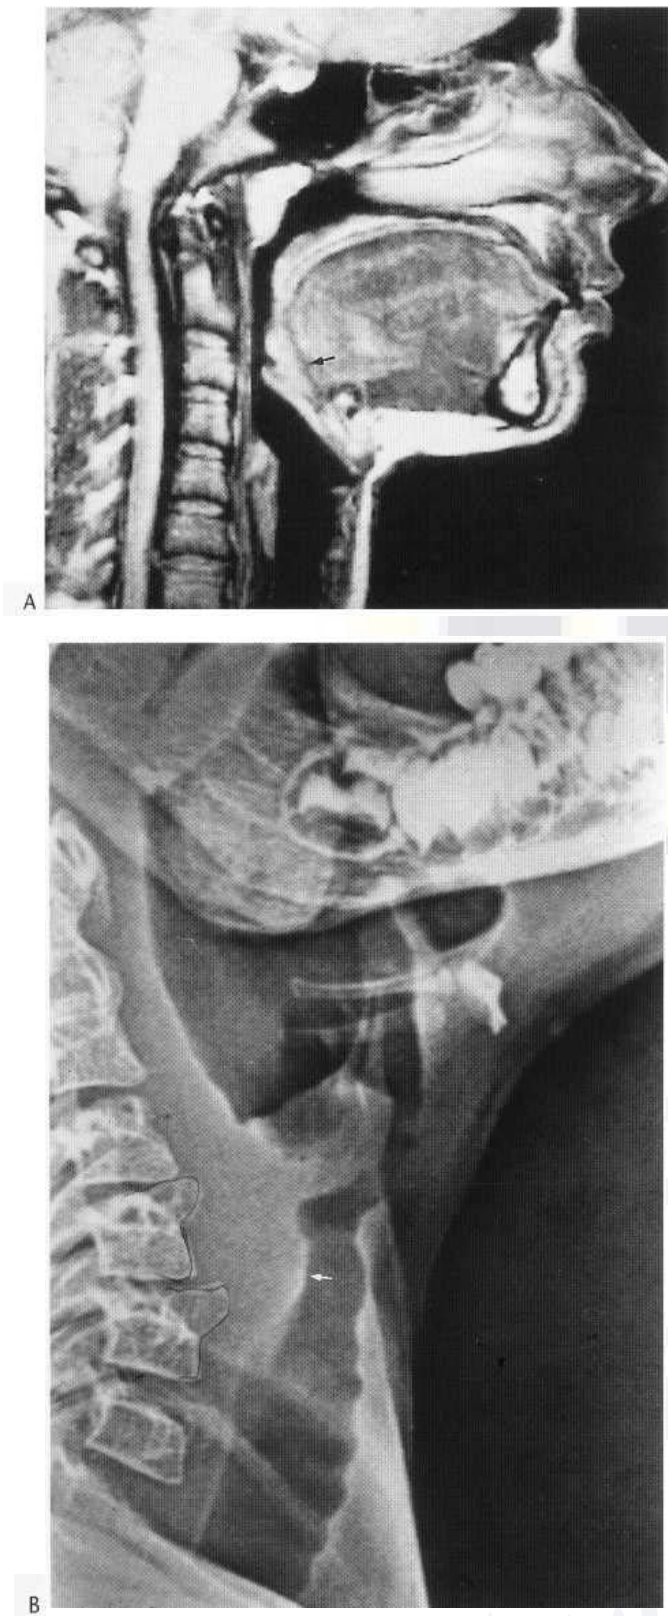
(A) Sagittal MRI, T₁-weighted, shows good differentiation between the tongue muscles, the genioglossi in the floor of the mouth and the surrounding fat, especially in the pre-epiglottic space (arrow). (B) Sagittal film in a child revealing subglottic stenosis (arrow).
